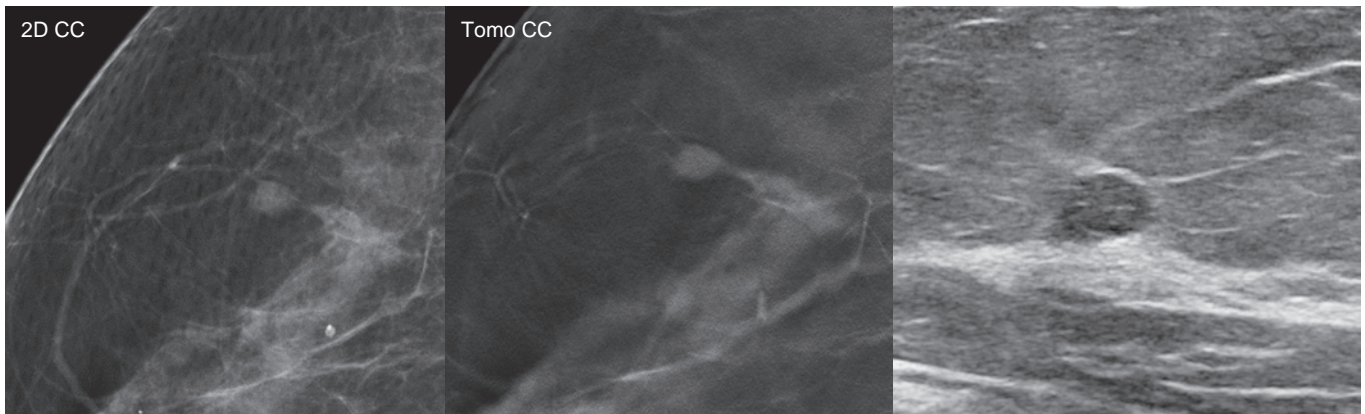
In the same patient from Fig. 9.1, close-up views of standard craniocaudal 2D and tomosynthesis views show circumscribed margins better defined on tomosynthesis. Targeted ultrasound confirms an oval circumscribed mass. Ultrasound-guided core needle biopsy yielded intraductal papilloma with atypical ductal hyperplasia, upgraded at surgery to grade 1 to 2 DCIS, ER/PR+.
